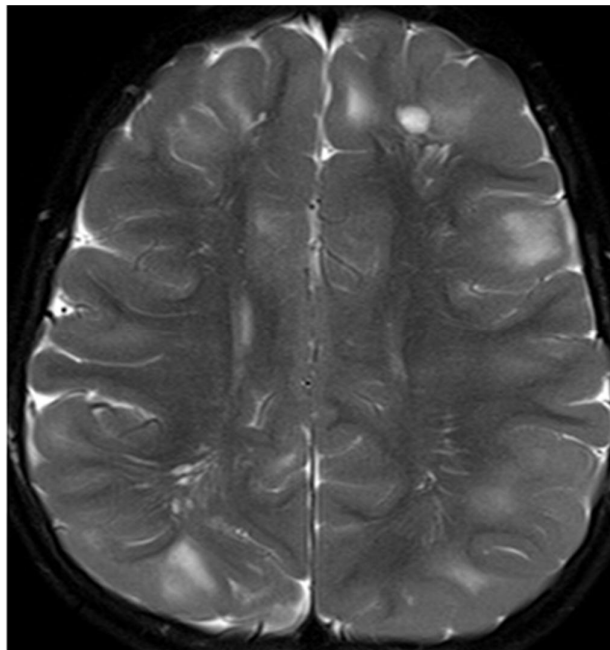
MRI Brain T2 Axial showing cortical tubers
